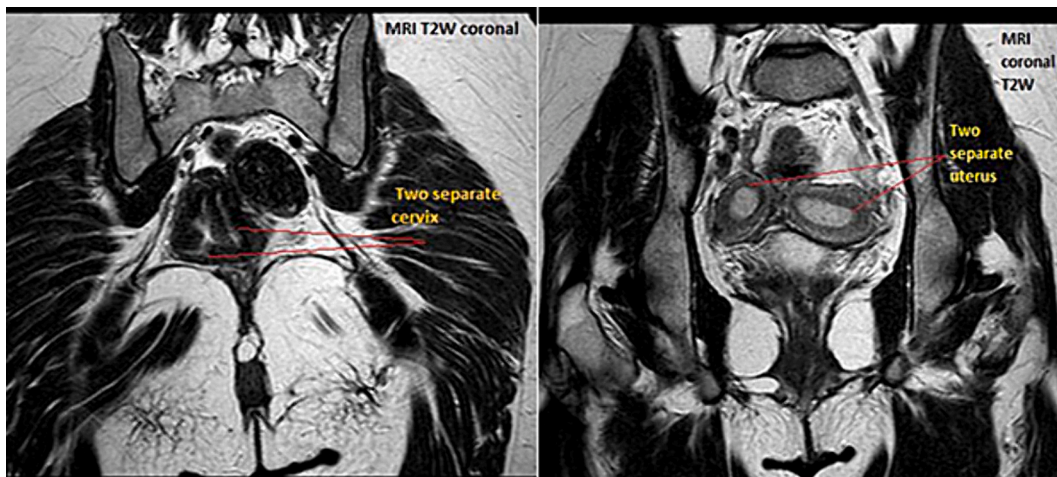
Follow-up MRI showing two separate uteri with widely divergent apices, and two separate cervixes, consistent with uterus didelphys.
